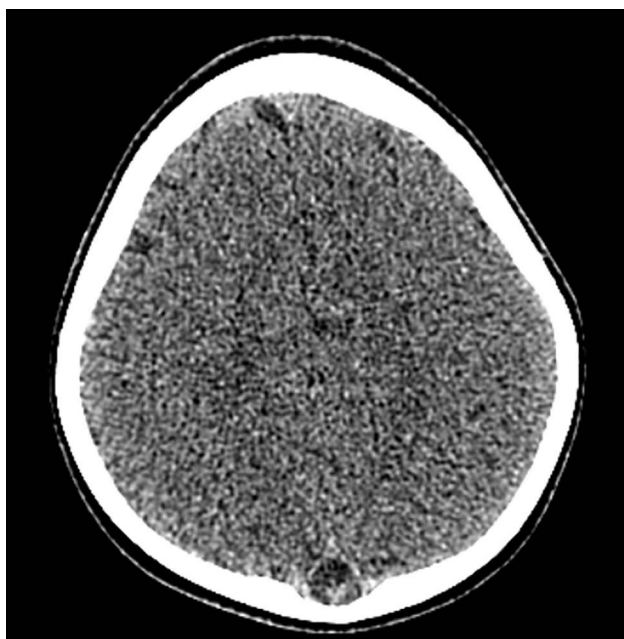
Suspected delta sign on the patient's axial multislice computed tomography.
